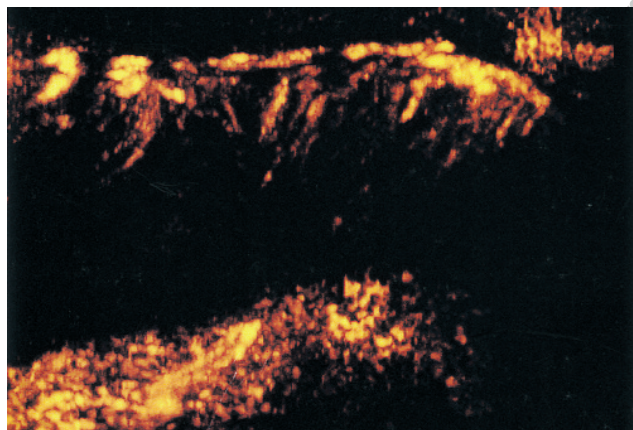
3D power Doppler image.
